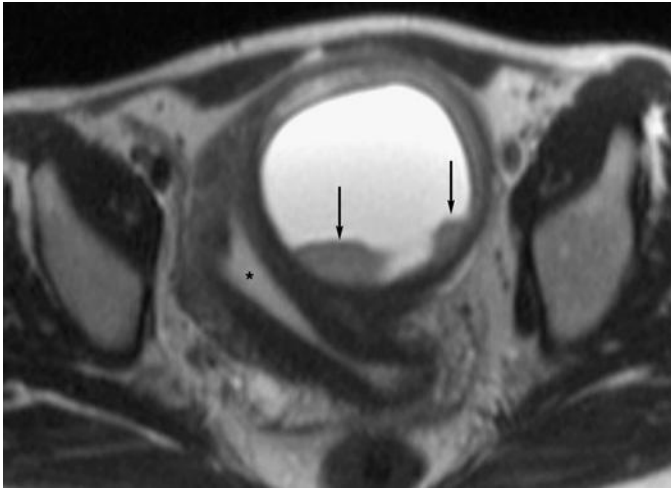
Uterine sarcoma. Axial T2-weighted image. The high signal intensity endometrial cavity (*asterisk*) is displaced by a large cystic (high signal intensity central component) myometrial mass that contains intermediate signal intensity mural nodules (*arrows*) posteriorly; pathologic examination proved the mass to be a uterine sarcoma.
